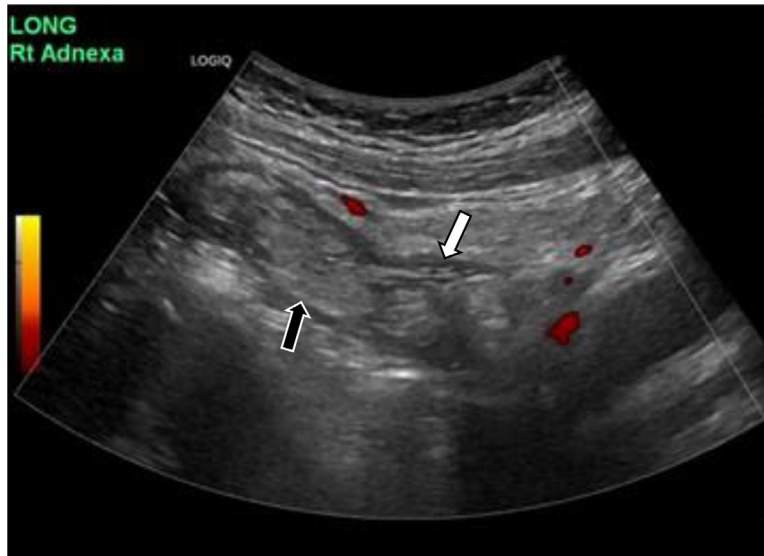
Color Doppler ultrasound image shows a dilated fallopian tube containing echogenic material consistent with macroscopic fat (black arrow) and linear echogenic foci suggesting hair (white arrow).
